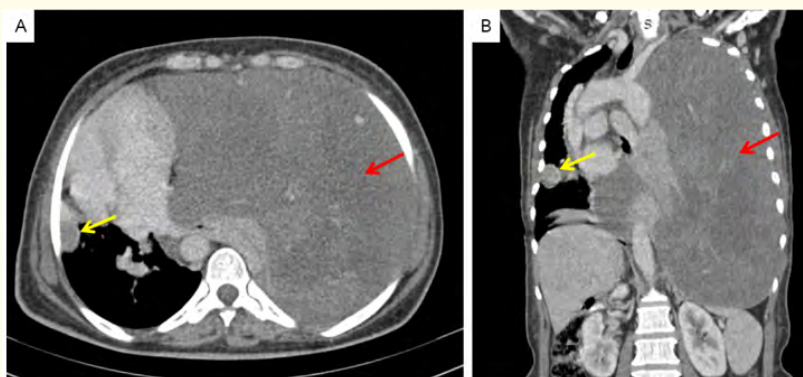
(A, B) Axial and coronal contrast-enhanced CT scans of the chest (mediastinal window): a large hypodense pulmonary mass with heterogeneous enhancement and central necrotic areas is observed (red arrow), associated with marked cardiac and mediastinal shift and a contralateral pleural nodule (yellow arrow).
